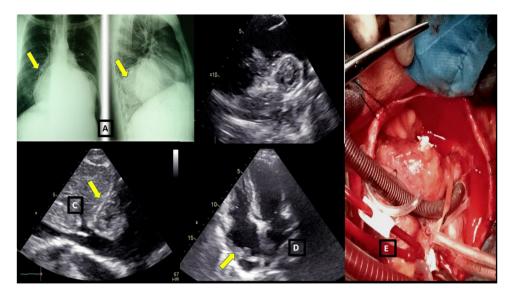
A: Chest radiography view showing a well-defined lesion in the right lower zone of the lung, and a cardiomegaly. B: Transthoracic echocardiography: Well-defined intramyocardial, multicystic heterogeneous mass, with a well-contrasted capsule, measuring 3.7×3.4 cm localized at to the lateral wall of the right atrium. This mass reaches the anterior tricuspid valvular. C: The mass (arrow) extends to the roof of the right atrium and exerts no compressive effect on the inferior venae cavae. D: Transthoracic echocardiography performed in post-operatively, apical 4-chamber view, persistence at the level of the roof of the right atrium of a hyperechoic image (blue arrow) corresponding to the pericardial patch reconstruction of the right atrium, pericardial effusion at the right atrium. E: Intraoperative photograph of intramyocardial right atrium hydatid cyst.
